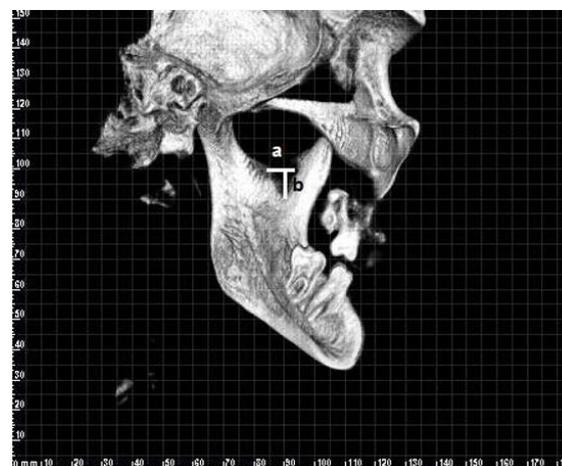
MDMR measurement: width (a), depth (b) on 3D CBCT images
